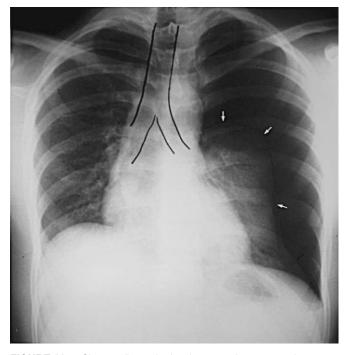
Chest radiograph showing a tension pneumothorax with mediastinal shift and deviated trachea. The trachea is outlined. *Arrows* indicate location of visceral pleura.
